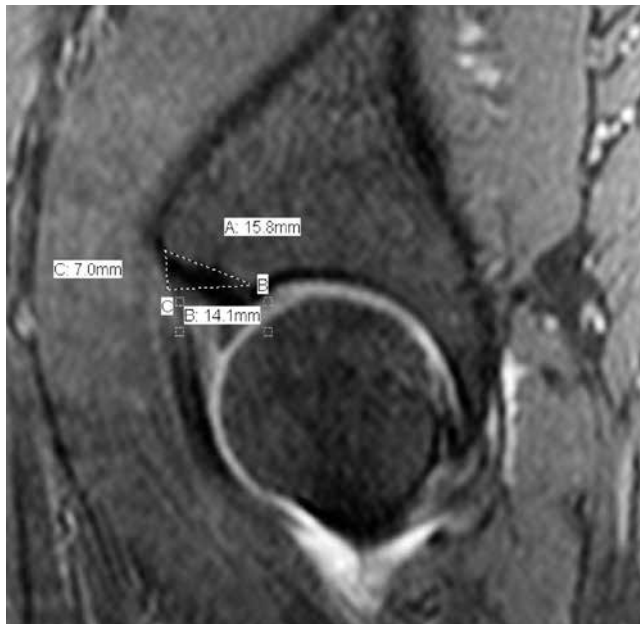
Measurement of the vertical (7.0 mm), horizontal (14.1 mm), and straight (15.8 mm) distances of the anterior inferior iliac spine from the acetabulum using sagittal view MRI.
